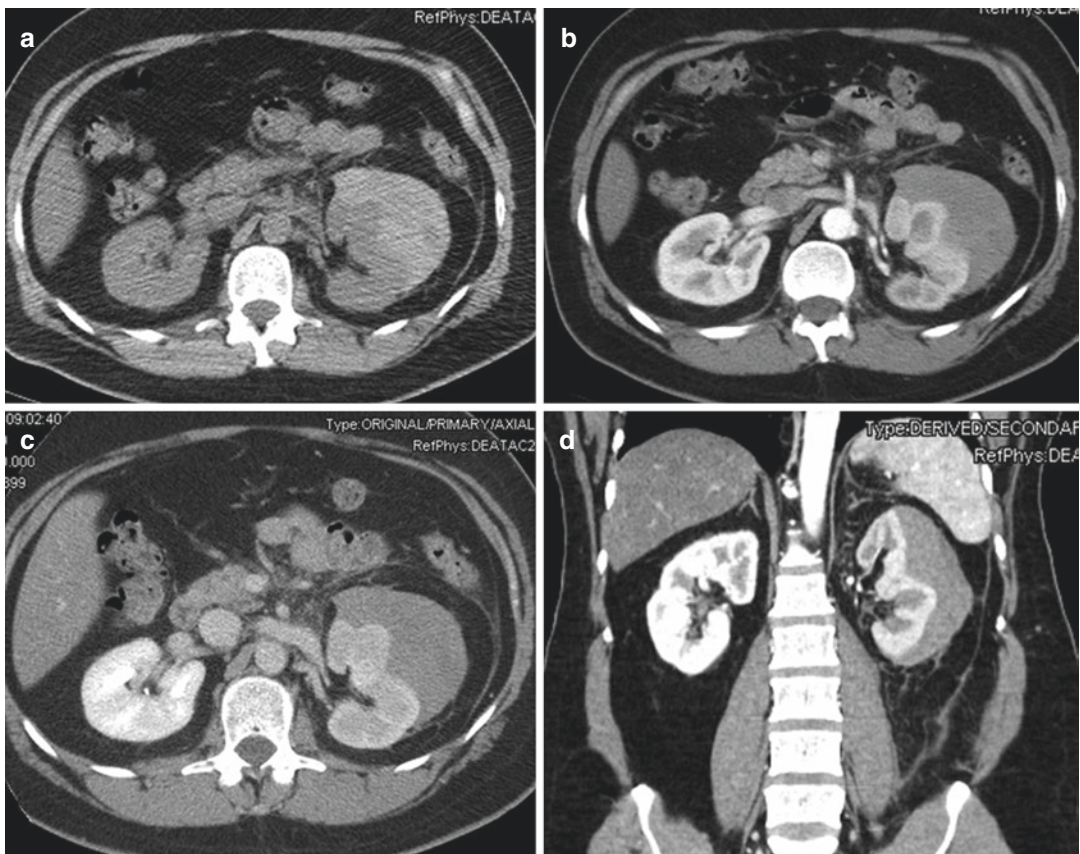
Same patient as Fig. 24.2. Multi-detector computed tomography (MDCT) performed on same day shows a large subcapsular hematoma in the left kidney, with parenchymal compression and delayed contrast medium elimination. There are no signs of active vascular
